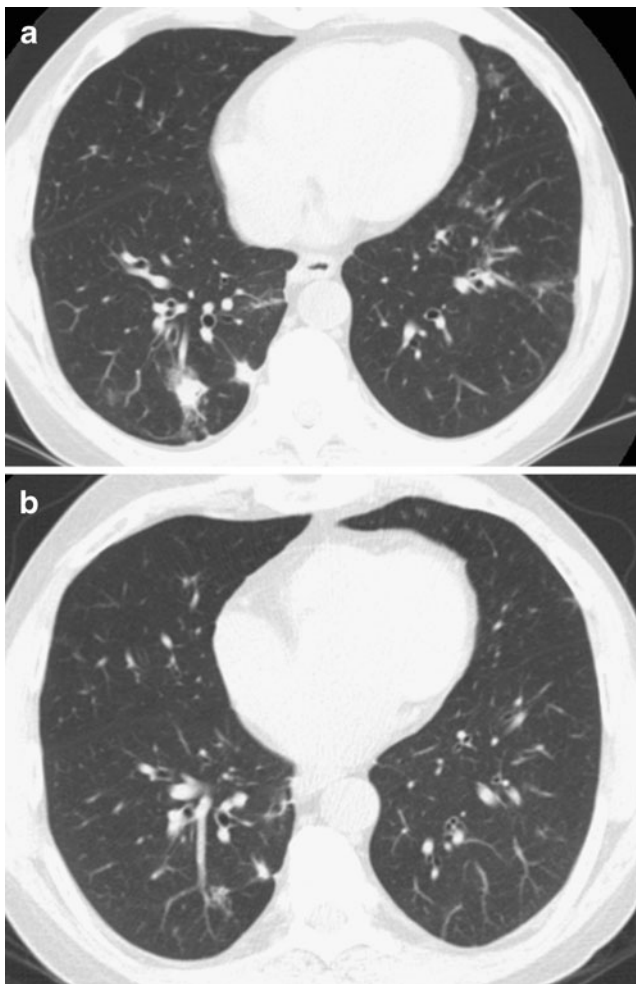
A 51-year-old, male, liver transplant recipient with novel influenza A (H1N1). a Initial CT demonstrates patchy peribronchial consolidation and GGO in the lower lobes. b Interval follow-up CT performed 26 days later shows near complete resolution of the previously seen abnormalities
